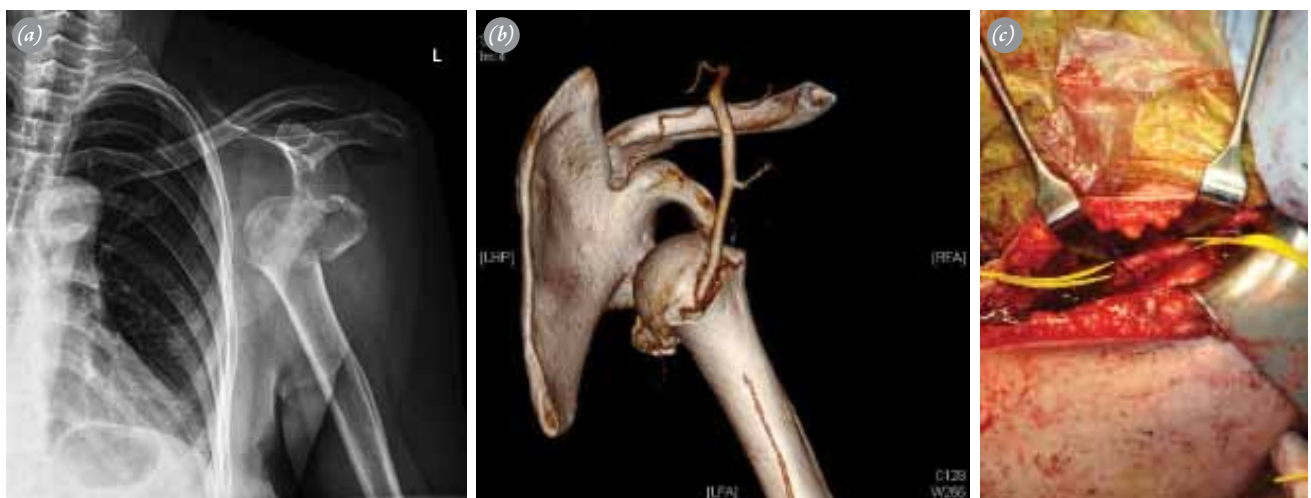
(a) Valgus-impacted humerus fracture with anterior dislocation of the shoulder; (b) Arterial occlusion due to compression or direct injury at the CT angiography. (c) Exploration of the axillary artery. [Color figures can be viewed in the online issue, which is available at www.aott.org.tr]
